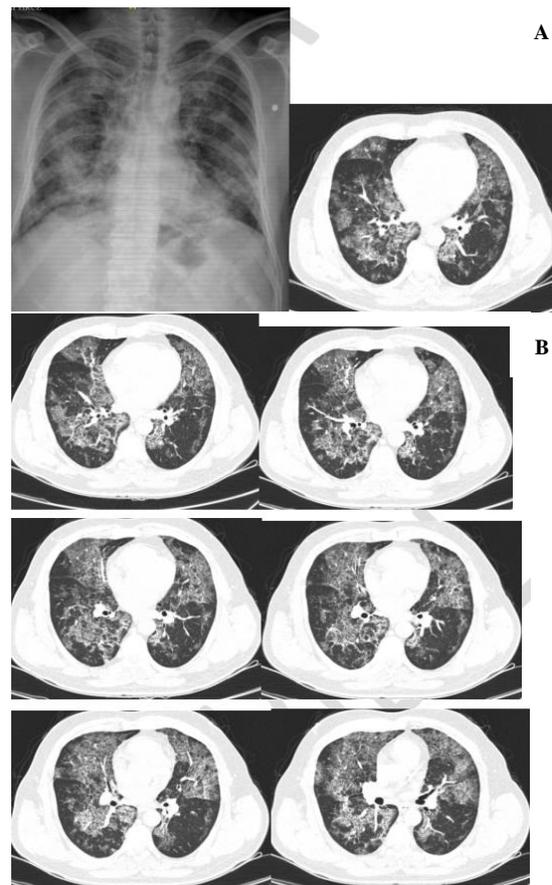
Chest X-ray and computed tomography (CT) scan shows ground-glass densities, largely in a continuous pattern with some thickened interstitial structures like polygonal forms, named as crazy-paving (A, B)
